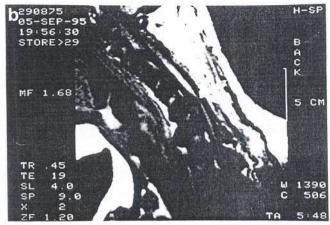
(a) Magnetic resonance imaging (MRI), transverse cut through the cervical spine showing calcification of the ligamentum flavum. (b) T1-weighted MRI of the cervical spine showing compression of the cervical spine at C5-6 level in twin A.
